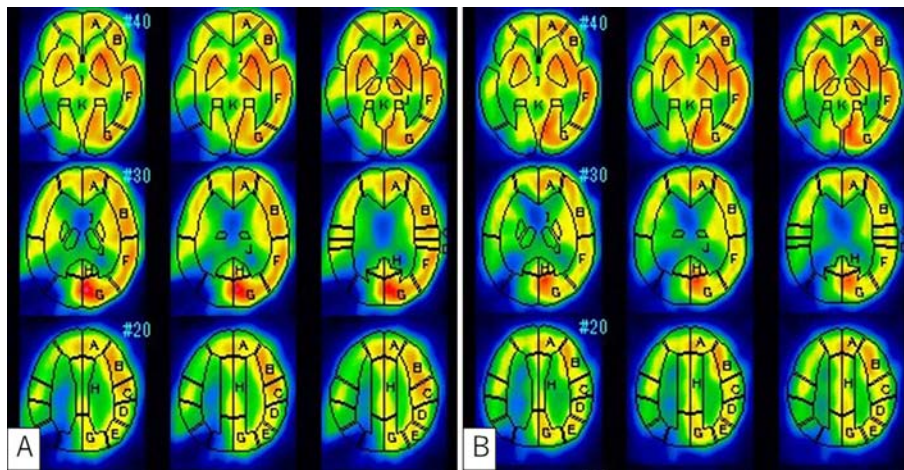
SPECT on admission (A) and five days after admission (B). Regional cerebral perfusion in the right parietal lobe is decreased. Five days after admission, there was an increased hypo-perfused area around the ischemic lesion.
